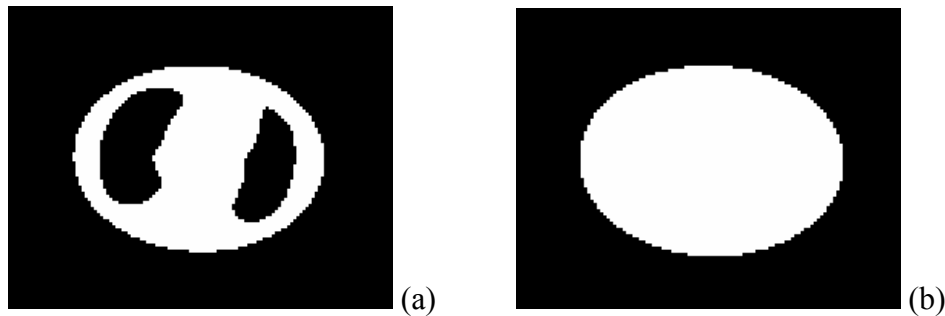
Left: binary CT slice with only tissue and lungs. Right: binary CT slice with closed lung regions.
